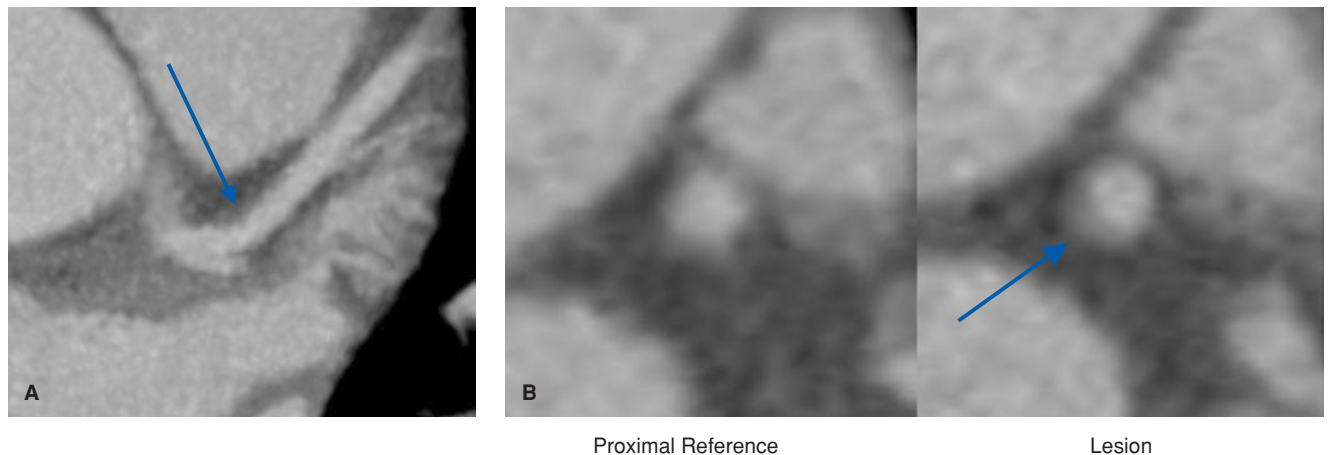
Proximal less than 50% stenosis diagnosed by coronary CTA. Double oblique maximum-intensity projection image (4 mm thick) through proximal LAD (A) demonstrates a segment of non-calcified plaque that is not associated with any significant luminal narrowing (*arrow*). True vessel short-axis multiplanar reformatted images through the lesion (B, *right*) and through the proximal reference segment (B, *left*) confirm minimal luminal narrowing. Low-density “noncalcified” plaque with positive vessel remodeling is seen (*arrow*). This case highlights the ability of CTA to detect early stages of subclinical atherosclerosis. This lesion may not have been detected during a conventional angiogram.
